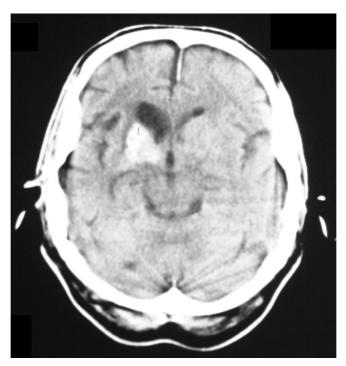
CT scan of the Brain on the 3rd November 2004 about a month after the initial presentation showing acute right basal ganglia bleed
